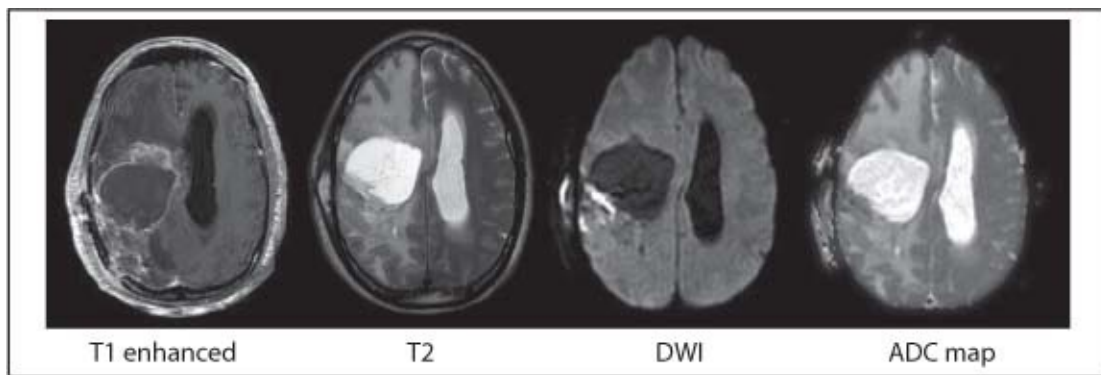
MRI of right hemispheric glioblastoma (dark on DWI)
